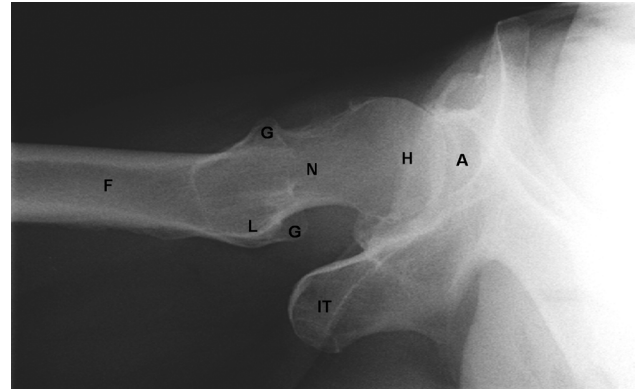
Danelius-Miller¹⁶ lateral radiograph of a female patient with osteoarthritis. F, femur; L, lesser trochanter; G, greater trochanter; N, neck of the femur; H, head of the femur; A, acetabulum; IT, ischial tuberosity.
